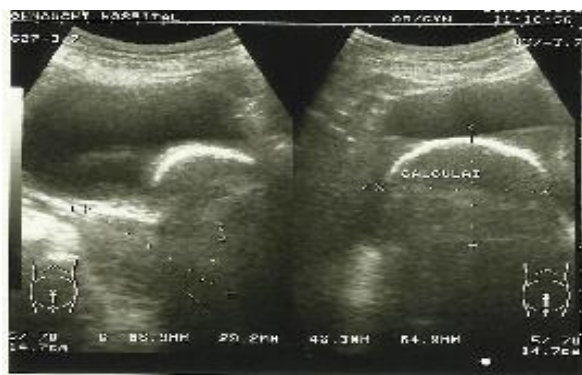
UltraSound Result
